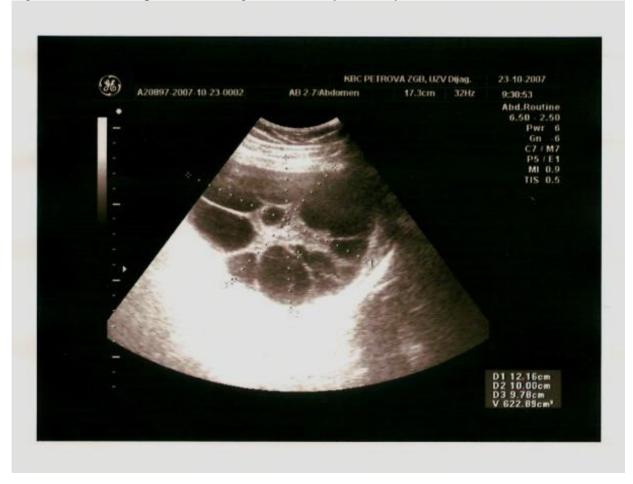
Ultrasound picture of enlarged and multicystic ovary
